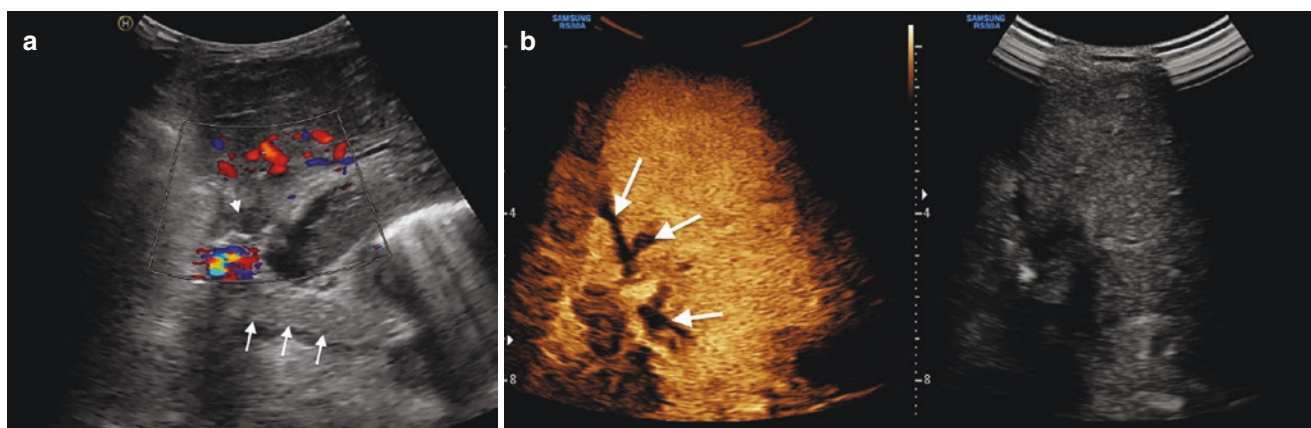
(a) US shows an echogenic thrombus within the extrahepatic portal vein (arrows), with extension into the intrahepatic portal veins and absent flow on colour Doppler (arrowhead). (b) CEUS shows the absence of enhancement of the portal vein and branches (arrows)
